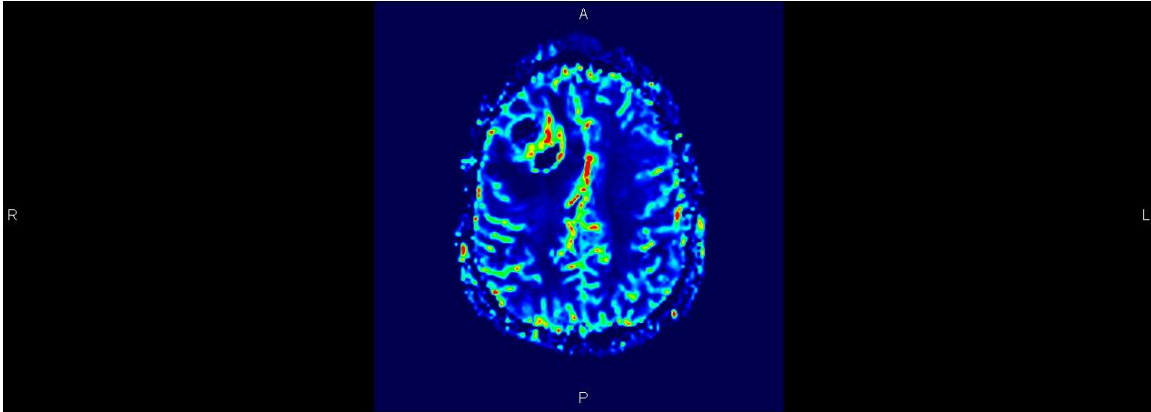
Axial DSWP (Dynamic Susceptibility Weighted Perfusion) MRI. (rCBF map). Increasing rCBF surrounding the tumor in the same area where the increase in rCBV was demonstrated.
